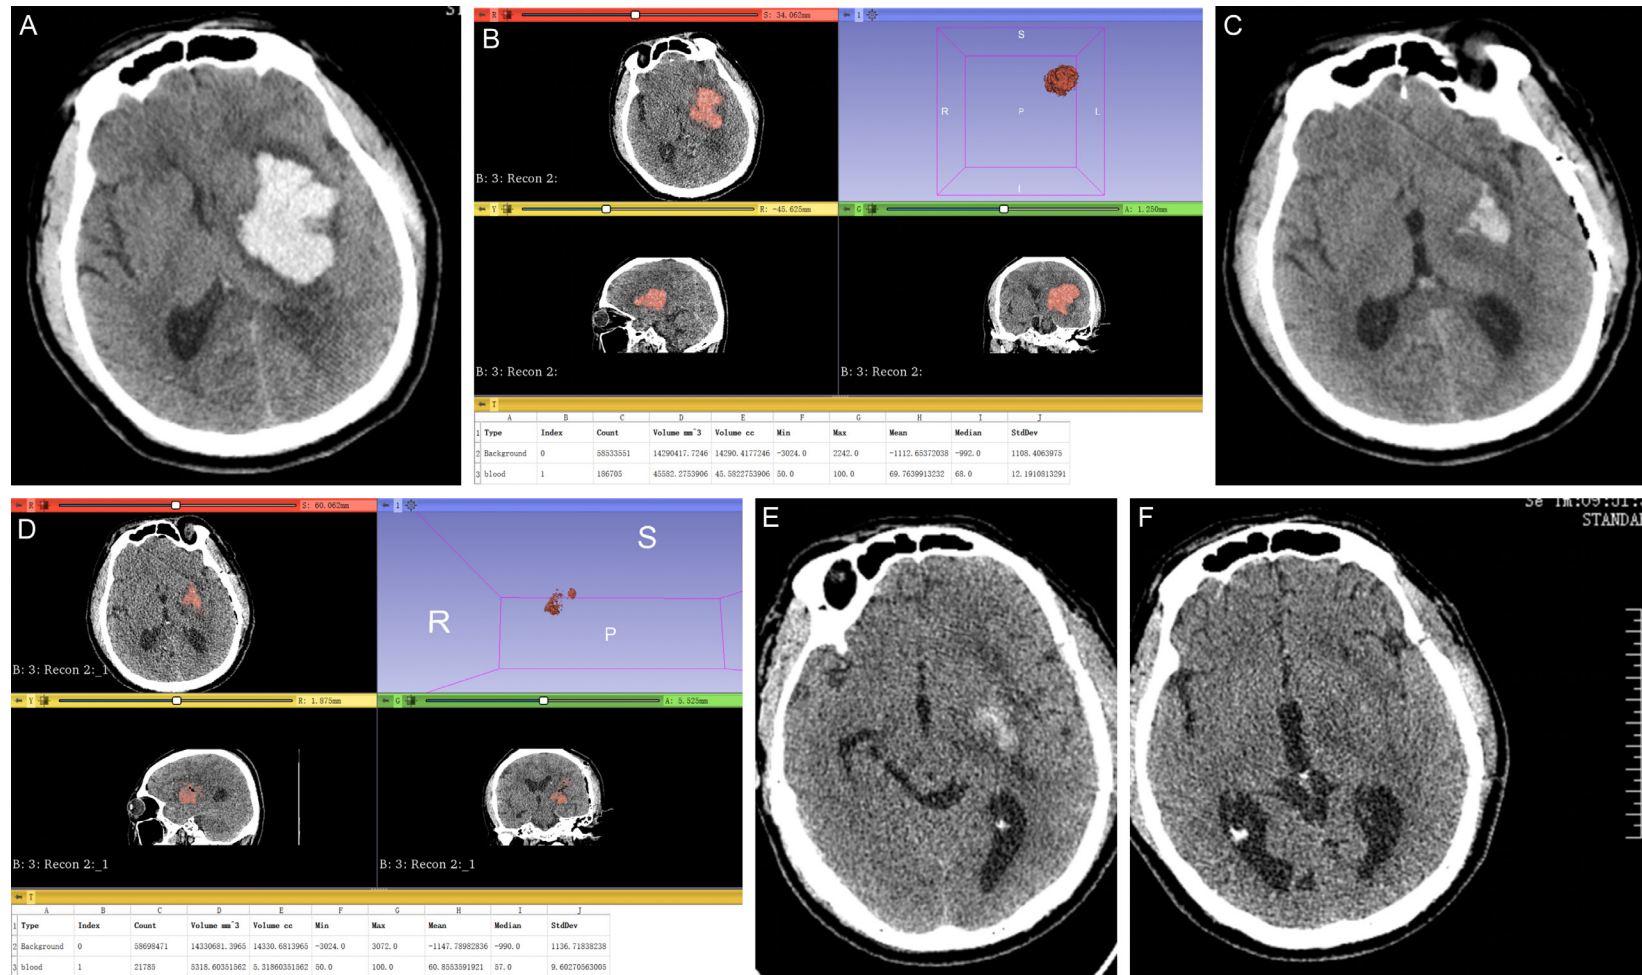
Craniotomy (ICH in the basal ganglia region). A. Preoperative head CT, intracerebral hemorrhage in the left basal ganglia area. B. The hematoma volume calculated by 3D-Slicer before operation. C. The head CT was reexamined on the day after operation, and the intracranial hematoma was cleared. D. The hematoma volume calculated by 3D-Slicer after operation, and the hematoma evacuation rate was $74.45 \pm 2.89\%$. E. Reexamination one week after operation CT revealed that most of the hematoma was absorbed. F. CT scan one month after the operation showed that the hematoma was completely absorbed.
